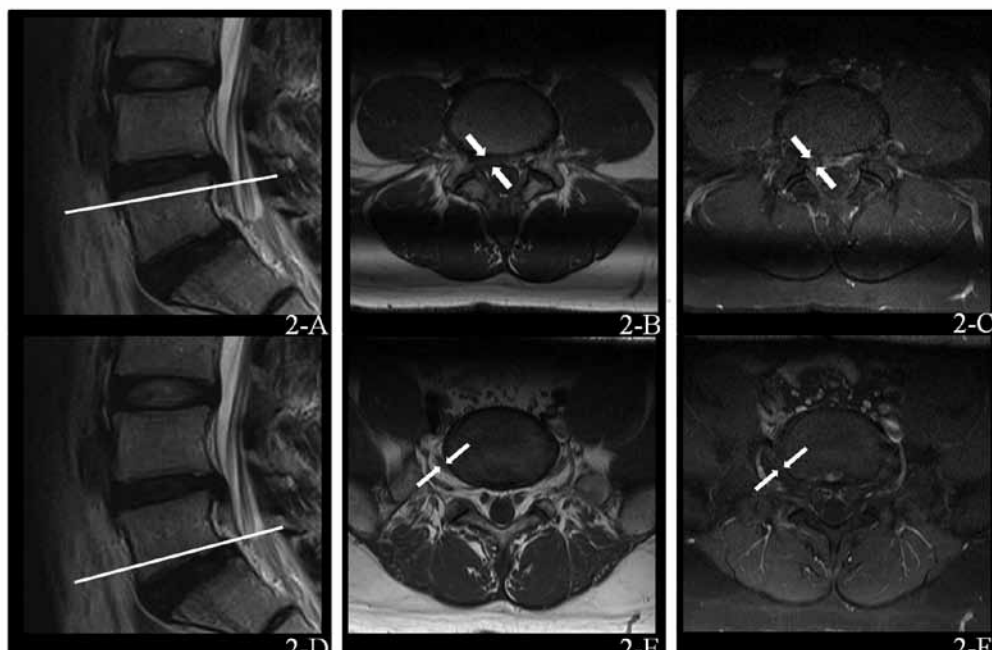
Non-enhanced nerve root in lumbar disc herniation. Contrast-enhanced MRI of a 37-year-old man shows a right paramedian extruded disc herniation without nerve root enhancement. At L5 pre-dorsal root ganglionic level (2-A), axial unenhanced T1-weighted (2-B), and contrast-enhanced T1-weight image (2-C) does not show nerve root enhancement. And, at L5 post-dorsal root ganglion level (2-D), axial unenhanced T1-weighted (2-E), and contrast-enhanced T1-weight image (2-F) also does not show nerve root enhancement.
